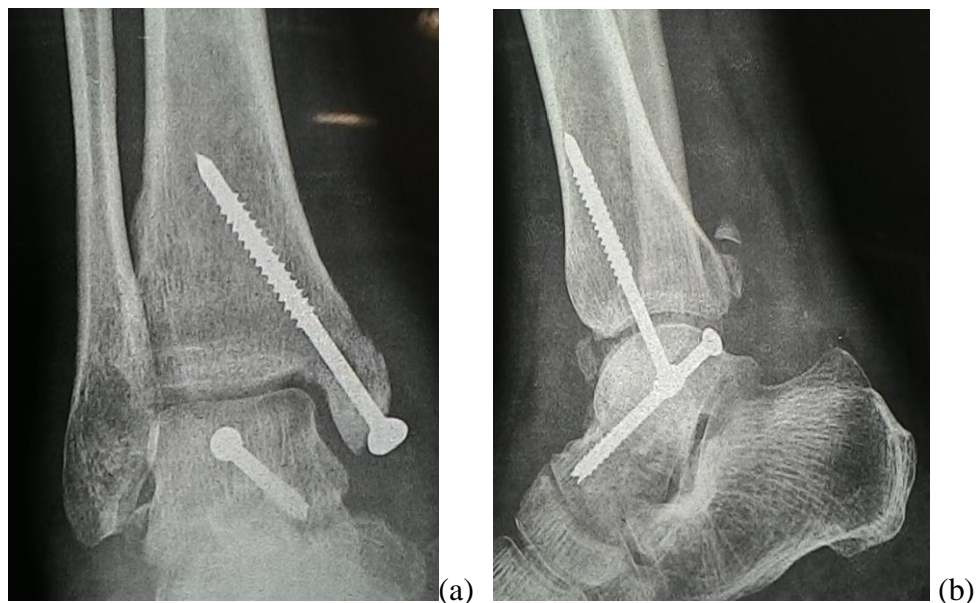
Radiograph at 3 months showing union
